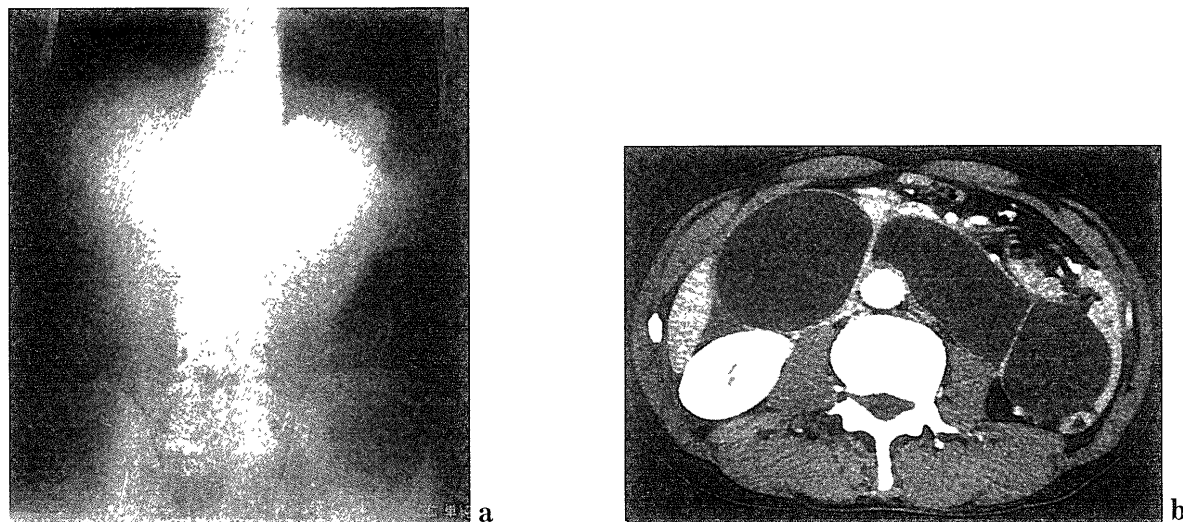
Plain abdominal X ray (a) and CT (b).
